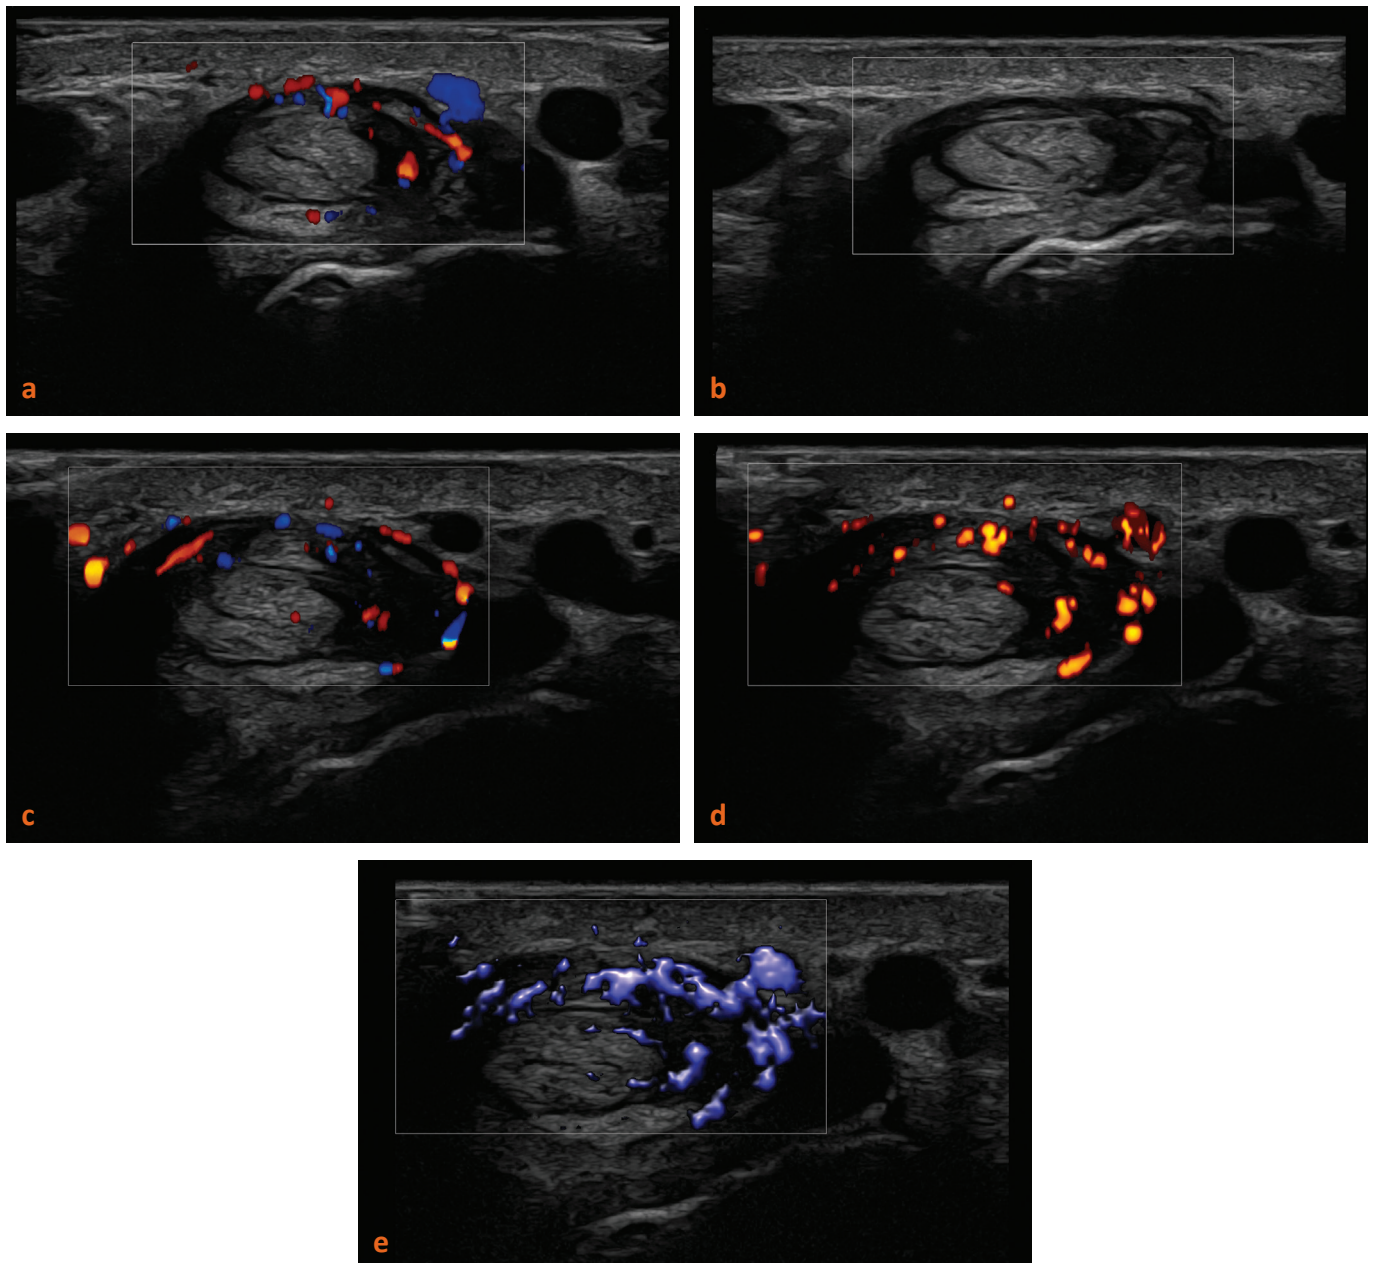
a-b: Scanning technique (Rule II). Don't apply pressure. (a) Transverse scan of extensor tendons with active tenosynovitis in a patient with Rheumatoid Arthritis (RA). Without applying pressure, the thickened synovium and vascularity are evident. (b) Pressure is applied. The synovium and increased vascularity are not visualized due to the pressure applied by the probe on the examined tissues ; c-e: Scanning technique (Rule III). Use flow imaging techniques. (c) Color Doppler Imaging depicts increased vascularity in the synovium of extensor tendons. (d) Power Doppler Imaging is more sensitive in depicting vascularity in the inflamed synovium. (e) Microvascular imaging is even more sensitive in the depiction of small vessels.
